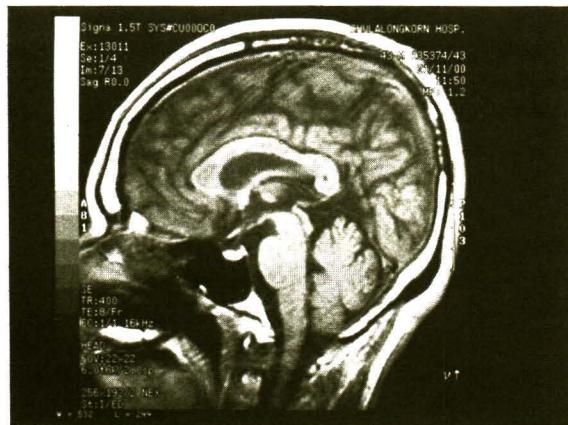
Sagittal T1WI MRI demonstrates abnormal hypointensity involving the central layer of the whole corpus callosum and a small cystic lesion in the splenium of the corpus callosum.
